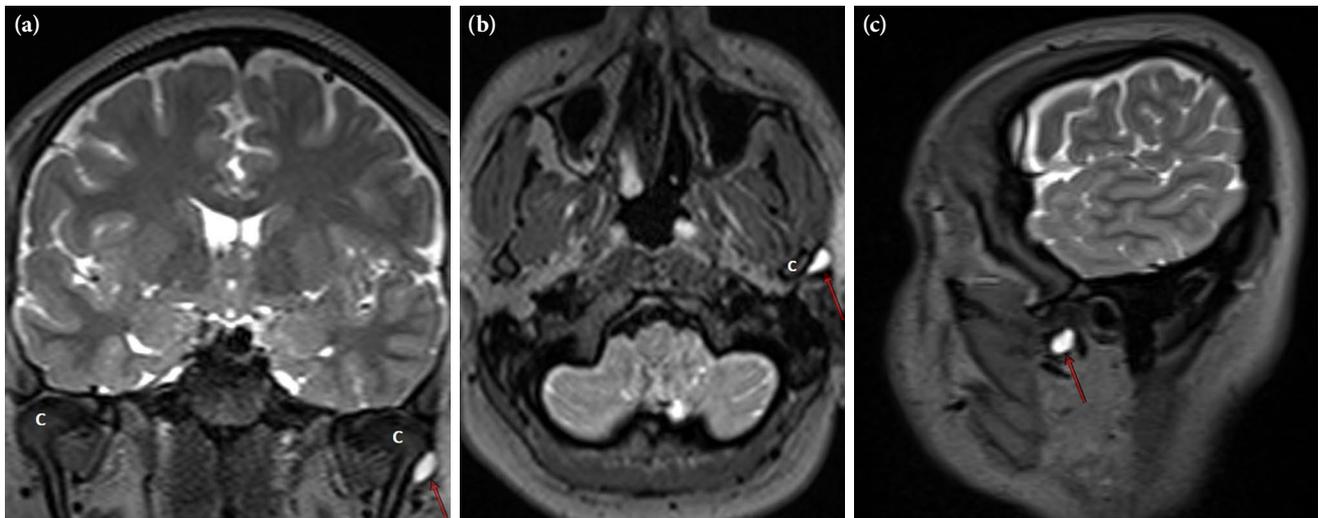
Coronal (a), axial (b), and sagittal (c) reformat T2-weighted SPACE MRI scans reveal a synovial cyst (red arrows) originating from the left TMJ.
